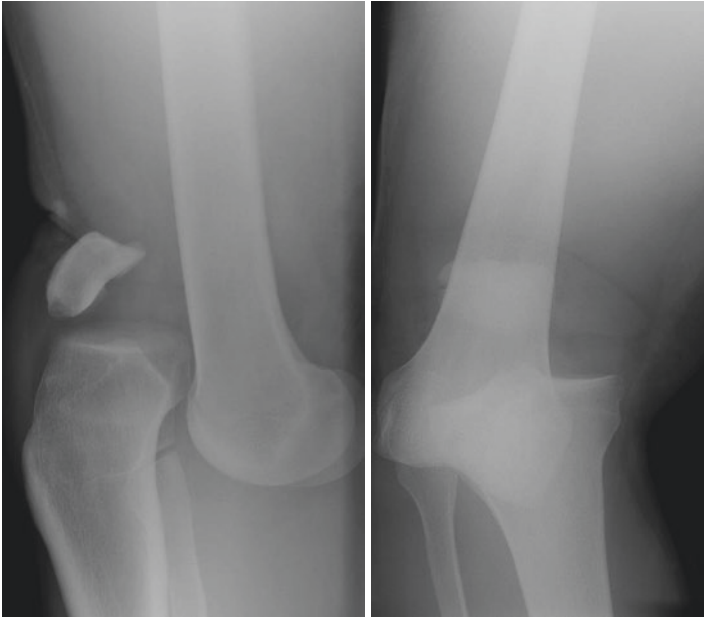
Representative radiographs of a patient with a multi-ligament injury of the knee (knee dislocations)
